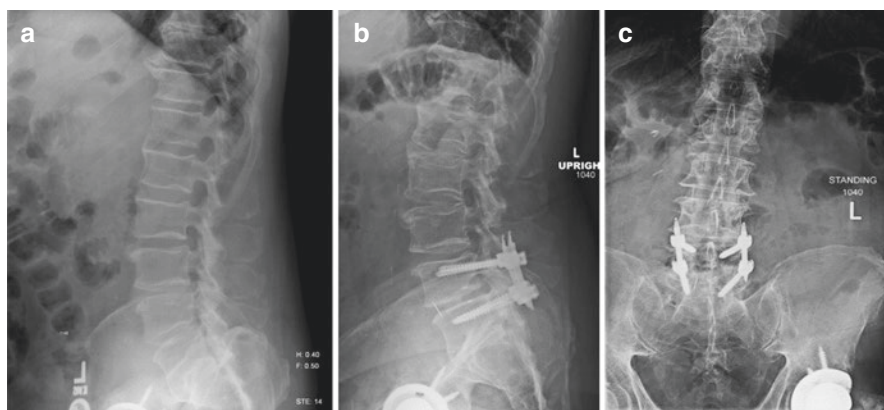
A 72-year-old male patient presenting with a 2- to 3-month history of low back pain radiating down to the right lower extremity. Preoperative X-rays (a) showed minimal endplate spurring with lower lumbar facet arthropathy and low-grade spondylolisthesis. The patient underwent L4-L5 posterior interbody lumbar fusion with use of a PEEK cage. Postoperative X-rays (lateral (b) and AP (c)) showed stable appearing lumbar fusion L4-L5
